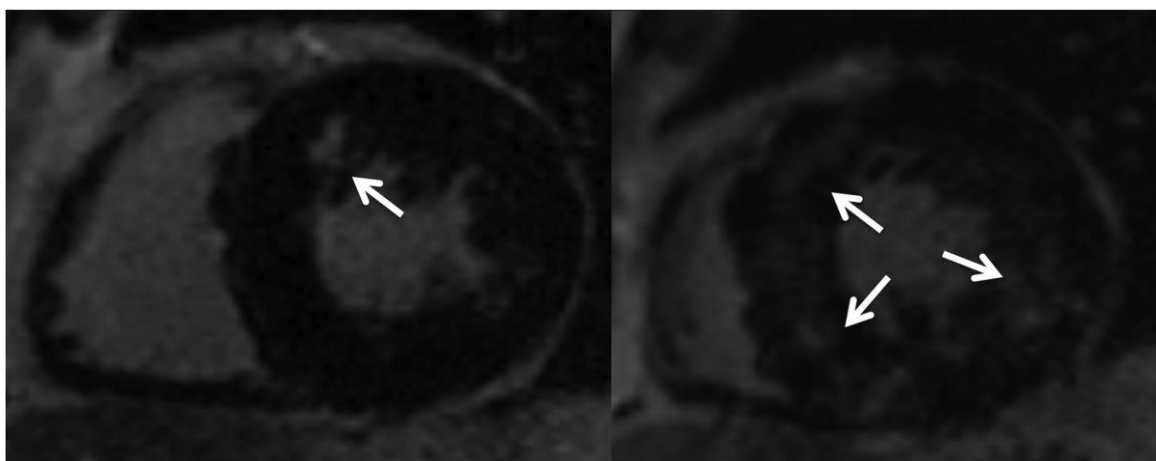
Examples of focal fibrosis demonstrated by Late Gadolinium Enhancement on MRI of patients with severe AS. Left: focal area of fibrosis at anterior right ventricle insertion point (arrow), Right: Patchy fibrosis throughout the myocardium.
